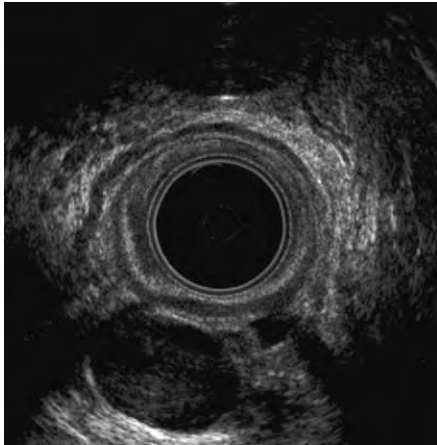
Retrorectal/presacral tumor. Note that the rectal wall is not involved on the basis of ultrasound assessment.
